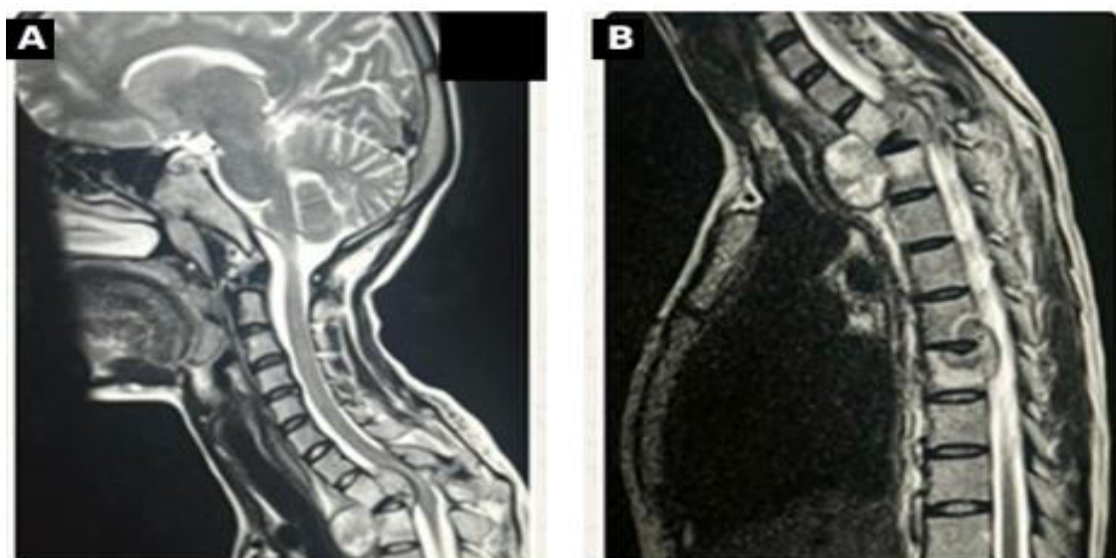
(A) Sagittal craniocervical MRI image showing cranial extension of disease and (B) sagittal cervicothoracic MRI image showing upper thoracic vertebral collapse with prevertebral and epidural collection causing anterior thecal sac indentation and cord compression.
